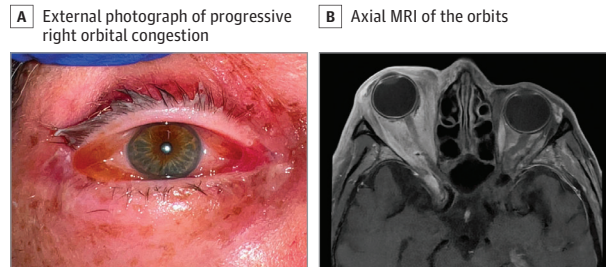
A, External photograph of the right eye demonstrating periocular edema, conjunctival injection, and chemosis. B, Axial T1 fat-suppressed postcontrast magnetic resonance imaging (MRI) demonstrating proptosis of the right eye with optic nerve straightening, diffuse enhancement of the right intraconal and extraconal fat, and periorbital tissues.
